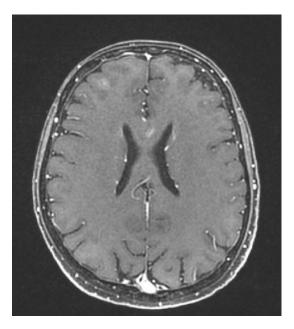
MRI pre-RT (frontal left brain metastases)
